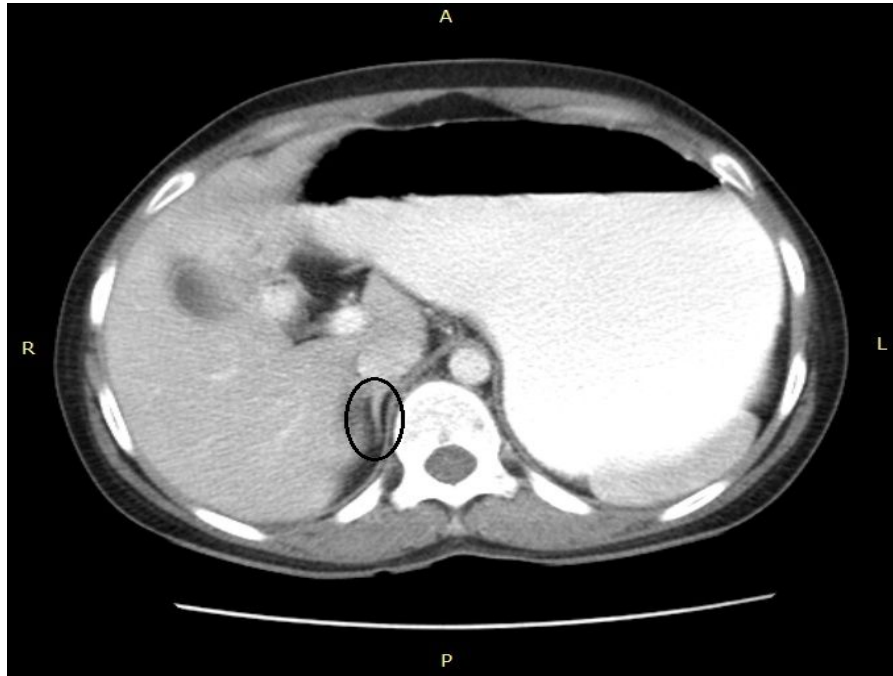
Axial CT image for Male (44 years) shows left adrenal gland (Y shape).
